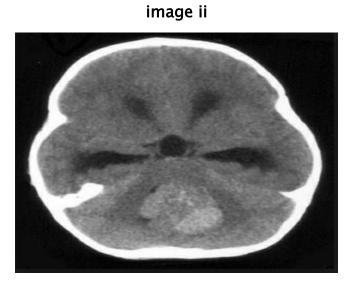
unenhanced CT scan image showing a slightly hyperdense image of medulloblastoma.
